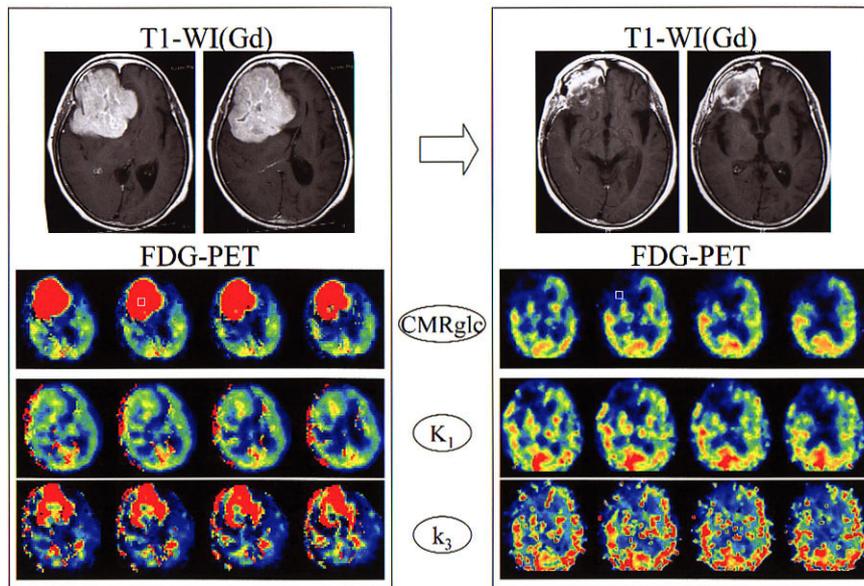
Axial MR and FDG-PET images before (*left panel*) and 21 days after (*right panel*) the chemotherapy in Case 2. Open squares indicate ROI for FDG-PET quantitative analysis. Before the chemotherapy, axial T1-weighted MRI with gadolinium showed a huge well-defined enhancing tumor in the right frontal lobe with substantial mass effect. The tumor exhibited markedly high FDG uptake relative to surrounding brain on FDG-PET images. Corresponding lesion showed slightly increased K_1 value in the center of the tumor and markedly accelerated k_3 value in the tumor except for the center in the kinetic analysis. Twenty-one days after the chemotherapy, the tumor volume was significantly reduced on gadolinium enhanced T1-weighted MRI. At the same time, the lesion showed substantially low FDG uptake relative to surrounding brain on FDG-PET images with decreased K_1 and k_3 values. The reduction of FDG uptake exceeded the volume reduction on MR imaging at this time.
